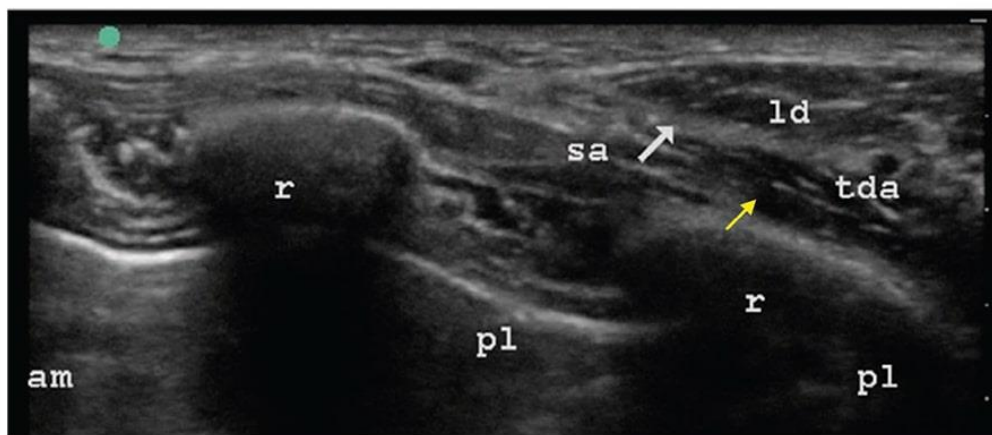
Ultrasound image demonstrating the serratus anterior muscle deep to the latissimus dorsi muscle and superficial to the ribs and the intercostal muscles. The yellow arrow indicates the fascial plane between the serratus anterior muscle and the rib, where the local anaesthetic should be deposited for the deep serratus plane block. The white arrow points to the fascial plane between the serratus anterior and the latissimus dorsi muscles, where the local anaesthetic should be deposited for the superficial serratus plane block. am, anteromedial; ld, latissimus dorsi; pl, posterolateral; r, rib; sa, serratus anterior; tda, thoracodorsal artery. [19].
